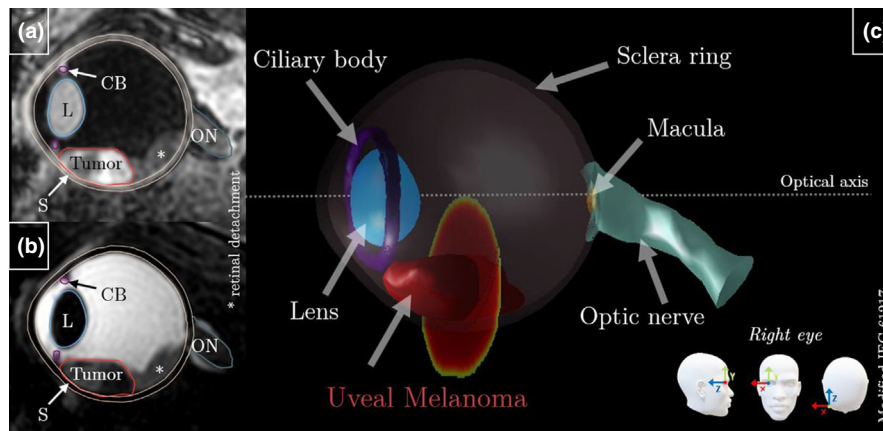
Demonstration of developed planning tools: three-dimensional (3D) T1- (a) and T2-weighted (b) magnetic resonance (MR)-slice showing the uveal melanoma and delineated MR ocular anatomical structures (ON: Optic nerve; L: Lens; CB: Ciliary body; S: Sclera ring. (c) 3D relative proton dose distribution within the 3D-MR-based reconstructed eye, calculated by π Dose. The macula is geometrically defined.
